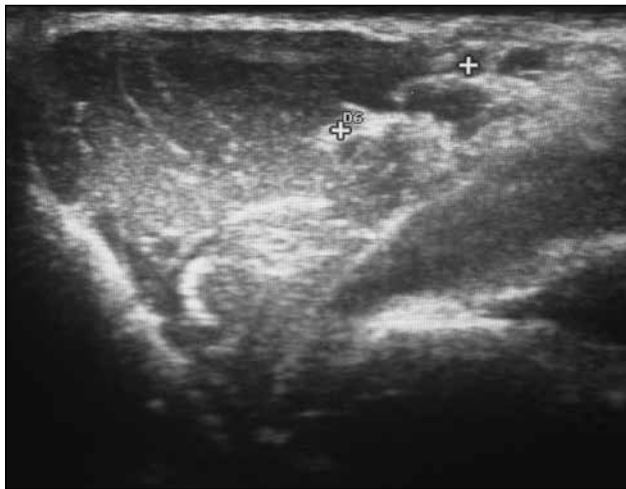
Ultrasonic view of axilla in the distal position. The median and musculocutaneous nerves were marked
